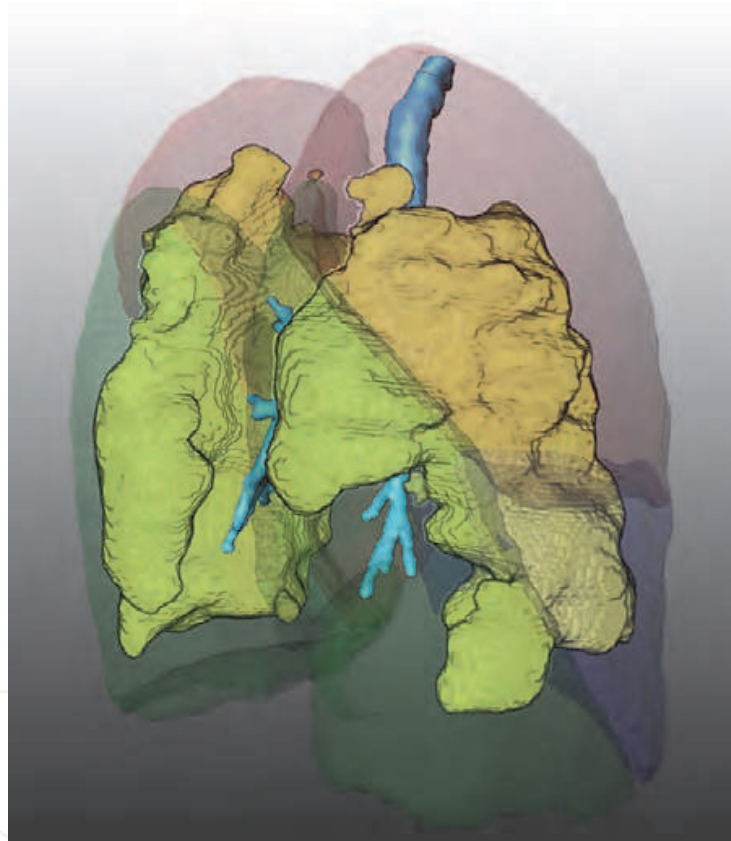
Three-dimensional visualization for a patient with severe lung emphysema. Software fusion of SPECT data set with CT data using ManualRegistration in MeVisLab. Ventilated areas are highlighted in colour, non-ventilated areas are depicted semitransparently.
